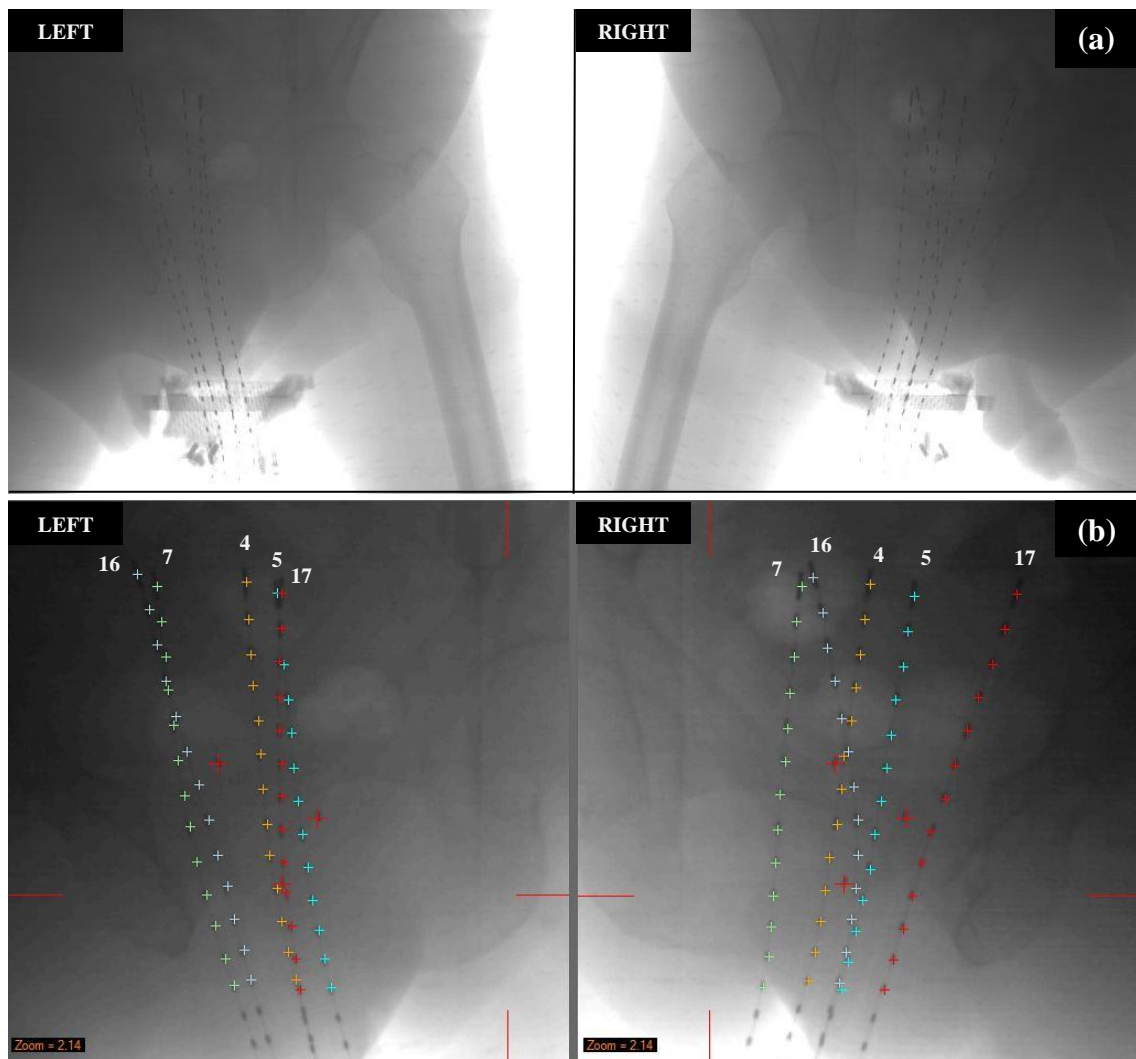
(a) The acquired ‘shift’ images of the patient prior to treatment captured with the x-ray source moved to the ‘LEFT’ and then ‘RIGHT’ of the patient. (b) The corresponding catheter marker points identified in each ‘shift’ image in preparation for 3D reconstruction. The fiducial marker points are also identified (large red crosses) in each image.
